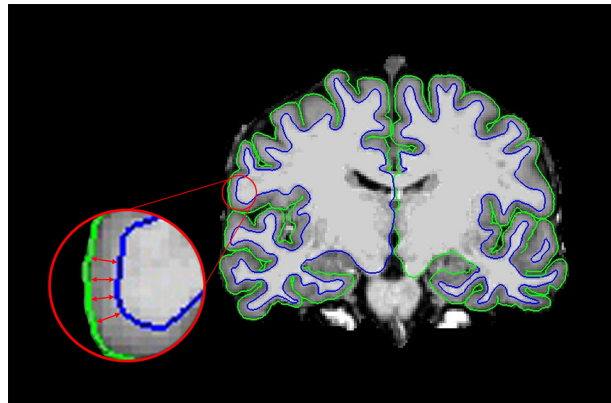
Representation of cortical thickness in the coronal plane from a T1-weighted MRI scan
